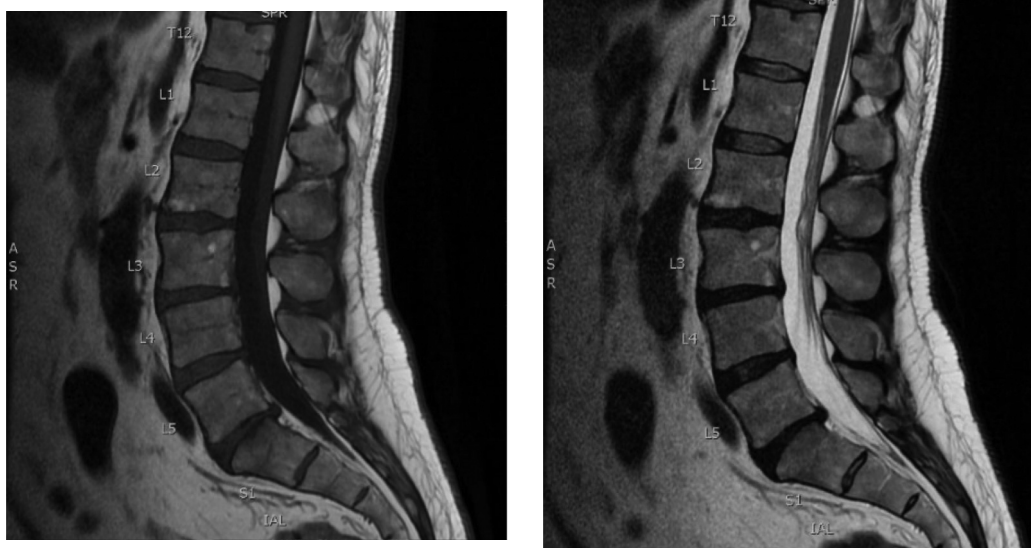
Panel A and B show magnetic resonance imaging (MRI) of the lumbar spine revealing hyperintense lesions at the L2 and L3 vertebrae consistent with Modic Type 2 changes. In the radiology report, these lesions were reported as Romanus lesions that may represent osteitis.
